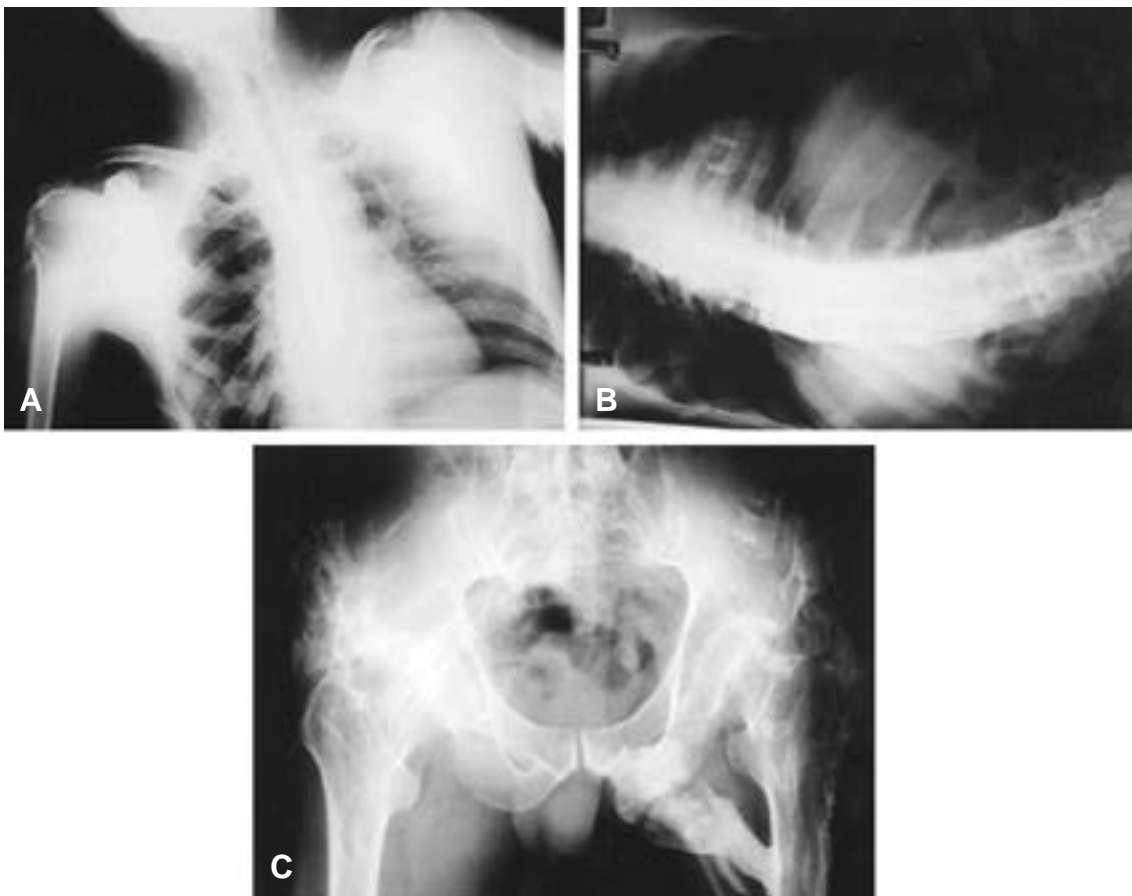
A 31-years old man with fibrodysplasia ossificans progressiva suffered from painful huge mass on left anterior chest wall. The simple X-rays show multiple heterotopic ossifications on chest wall and both shoulder girdles and superior migration of both humeral head (A), severe scoliosis with ankylosis (B), severe heterotopic ossification and loss of the left hip joint space (C).
